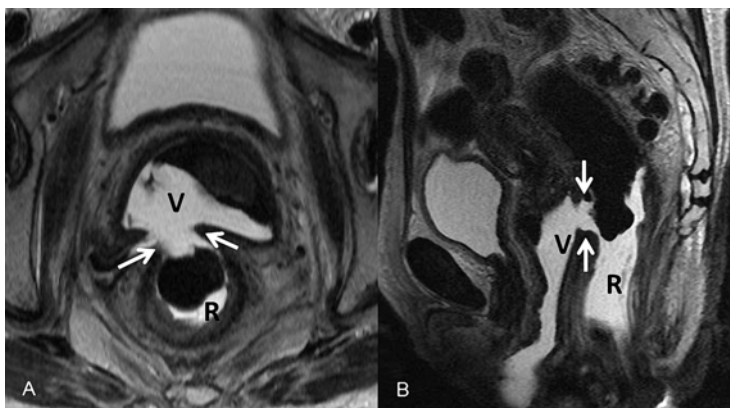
T2-weighted axial (a) and sagittal (b) MR images in a patient with a prominent rectovaginal fistula which developed following radiation of a rectal adenocarcinoma. T2 hyperintense rectal contrast (ultrasound gel) was administered prior to imaging and can be seen extending from the rectum (R) through the fistula (white arrows) into the vagina (V)
